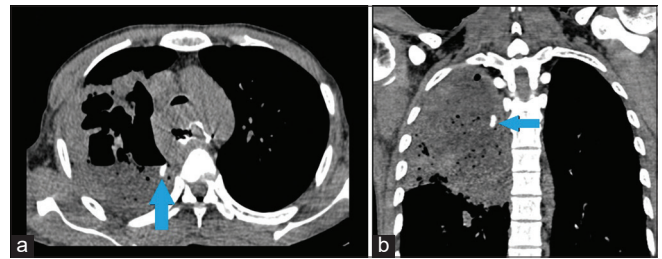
(a and b) Axial and coronal contrast (oral) multi-detector computed tomography scan images of thorax showing extravasation of oral contrast into the lung cavity (arrows), suggestive of esophago-pulmonary fistula
